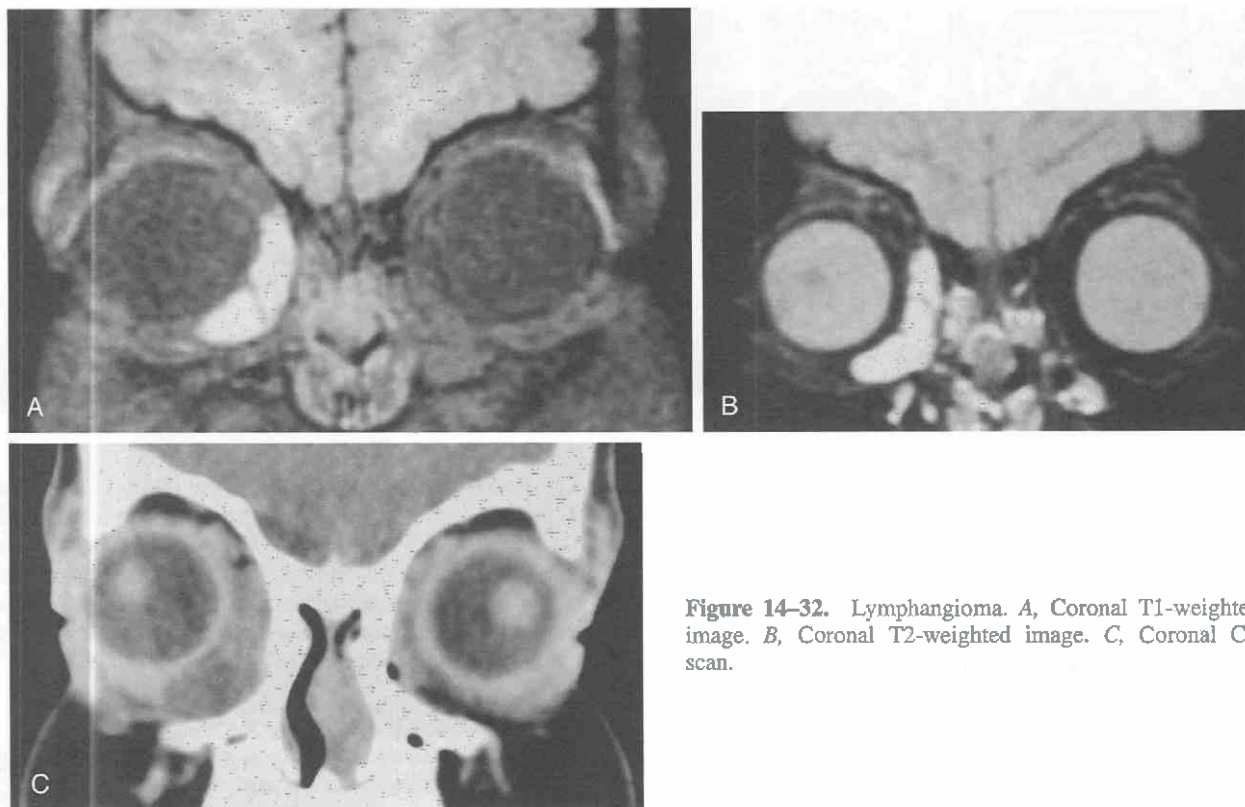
Lymphangioma. A, Coronal T1-weighted image. B, Coronal T2-weighted image. C, Coronal CT scan.
